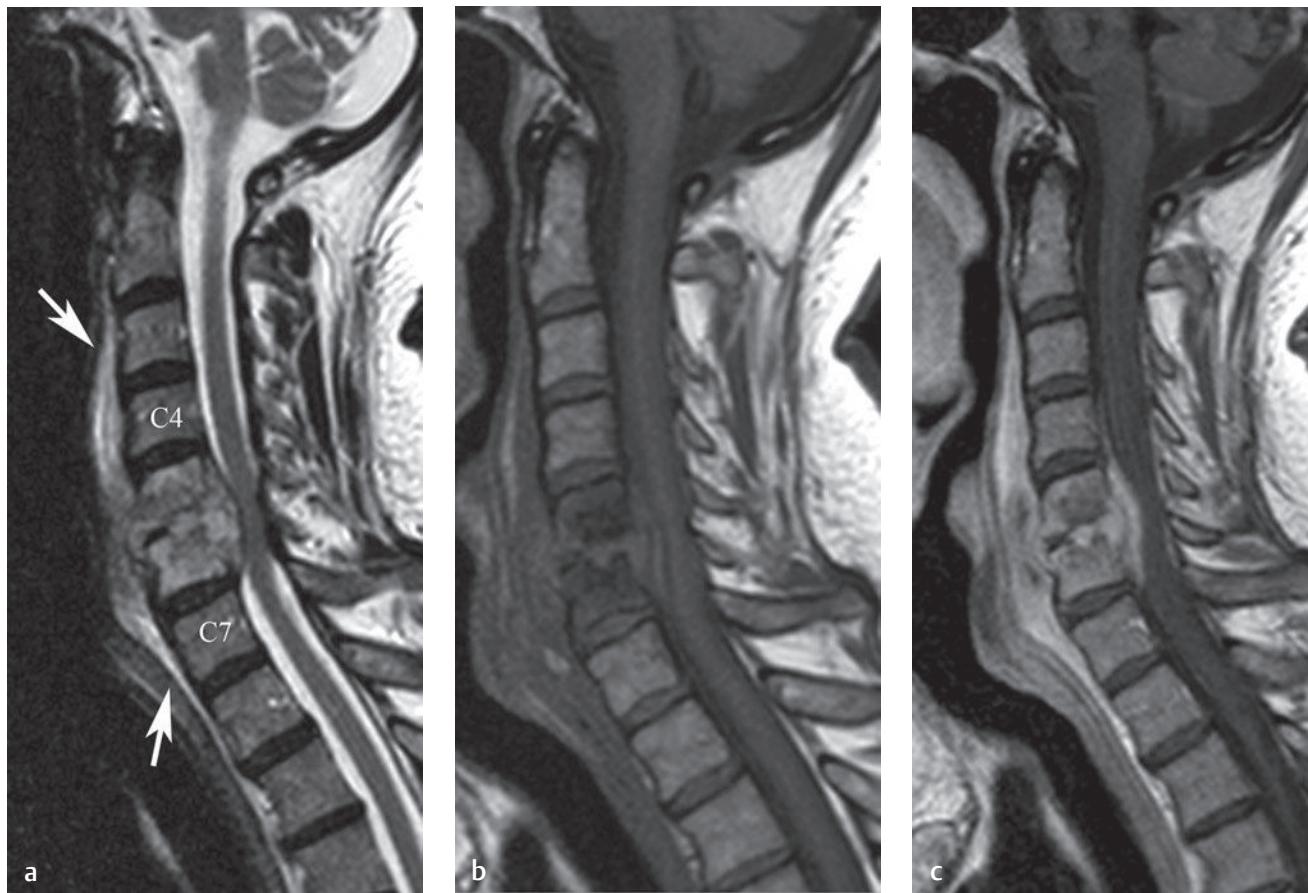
Cervical spine discitis and osteomyelitis. (a) A sagittal T2-weighted image shows obliteration of the C5-C6 disc space with associated edema in the C5-C6 vertebral bodies and an associated epidural component, which produces moderate spinal stenosis in a patient with infectious symptoms and findings. Note the prevertebral edema and soft-tissue fullness (between *arrows*). (b) Pregadolinium and (c) postgadolinium T1-weighted images show enhancement at the disc space, in the vertebral body's epidural component, and in the prevertebral space.[†]
